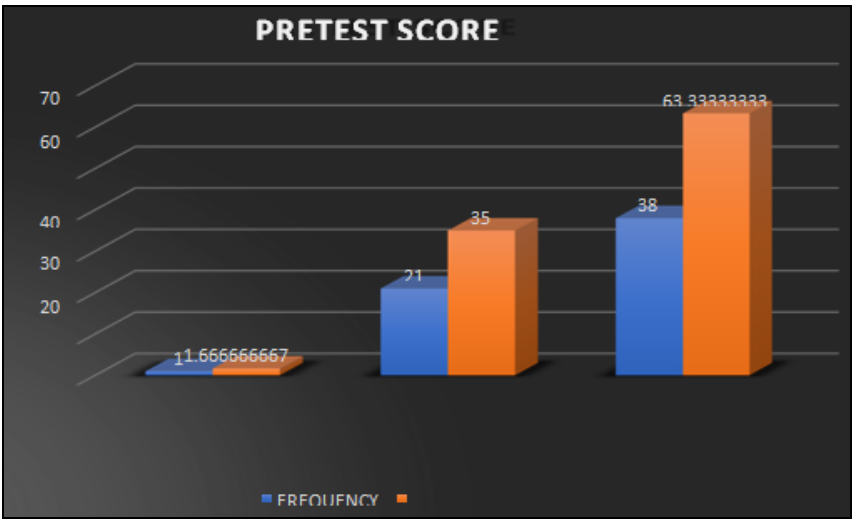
REVEALS THAT OVERALL PRETEST KNOWLEDGE SCORE OF PARENTS, IT SHOWED ONLY 1 (1.66%) HAD GOOD KNOWLEDGE SCORE, 21 (35%) HAD AVERAGE KNOWLEDGE SCORE AND 38 (63.33%) HAD POOR KNOWLEDGE SCORE. MEAN & STANDARD DEVIATION IS 4.91 & 2.59 RESPECTIVELY.
